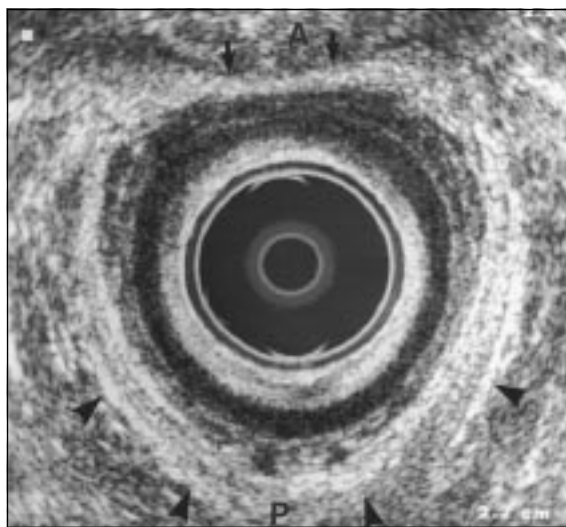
Ultrasound scan showing a normal anal canal. The ultrasound probe is central; the dark ring is the internal anal sphincter and the white structure surrounding it is the external anal sphincter muscle (arrows indicate outer limits). A = anterior, P = posterior
